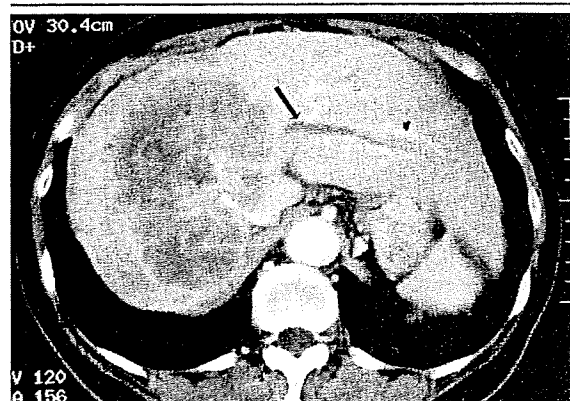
A 75-year-old female with cholangiocarcinoma. Intravenous contrast-enhanced CT scan of the upper abdomen demonstrating a huge solid mass, 10.0x9.0cm in size with peripheral enhanced areas in the right lobe of the liver. Involvement of the umbilical portion and slight dilation of the bile duct in Segment 2 is visible (arrow).
